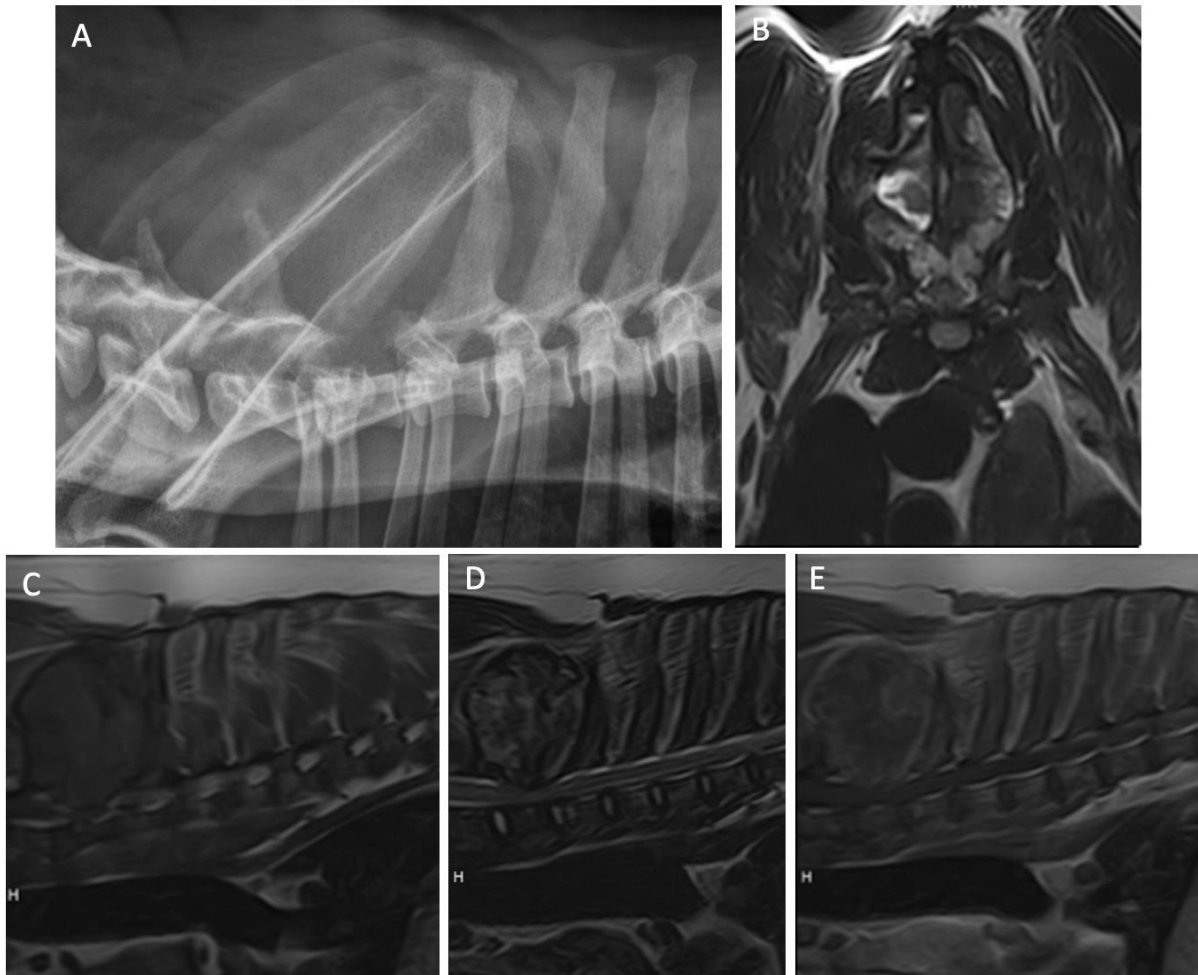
Thoracic Radiograph and Magnetic Resonance Imaging (MRI). (A) Right lateral radiographic projection: a collimated right lateral radiographic projection of the cranial thoracic vertebral column shows an aggressive, monostotic, lesion with complete lysis of the T1 spinous process and laminae. (B) MRI T2w image transverse (C) MRI T2w sagittal image of the cranial thoracic vertebral column show a heterogenous mass centered on and completely obliterating the T1 spinous process and pedicles with involvement of the dorsal laminae and invading the vertebral canal. (D) MRI T1w sagittal and (E) T1w sagittal post intravenous gadolinium contrast administration identified a moderate, predominately peripheral, contrast enhancement of the mass.
